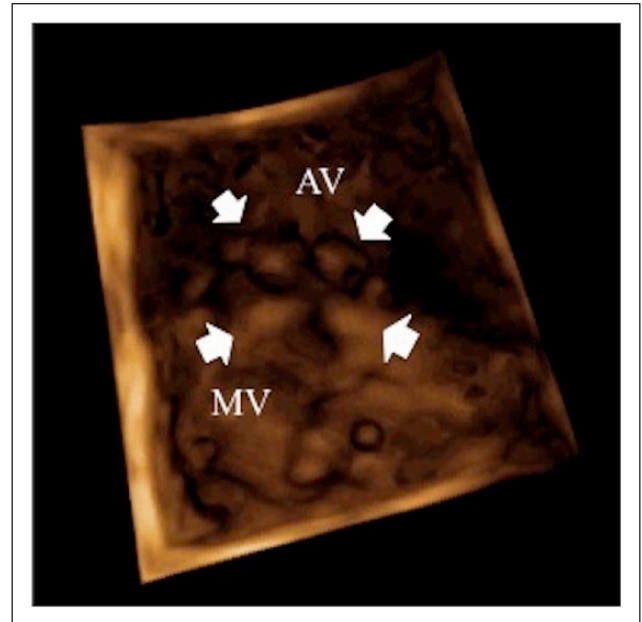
Real-time three-dimensional echocardiographic images after sedation with medetomidine and midazolam. The aortic valve (AV) and mitral valve (MV) were viewed from below during diastole. The aortic valve comprises four cusps (arrows)
